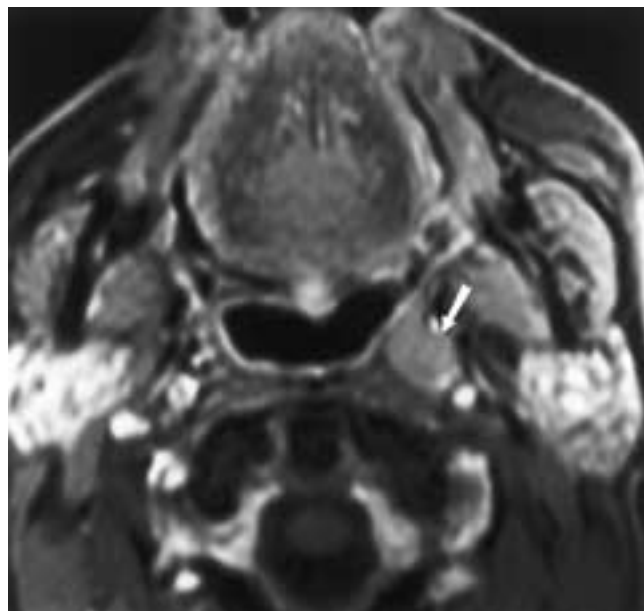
Metastatic papillary carcinoma in a retropharyngeal node. Enhanced fat-suppressed axial T1-weighted MR image shows a metastatic retropharyngeal lymph node (*arrow*).
